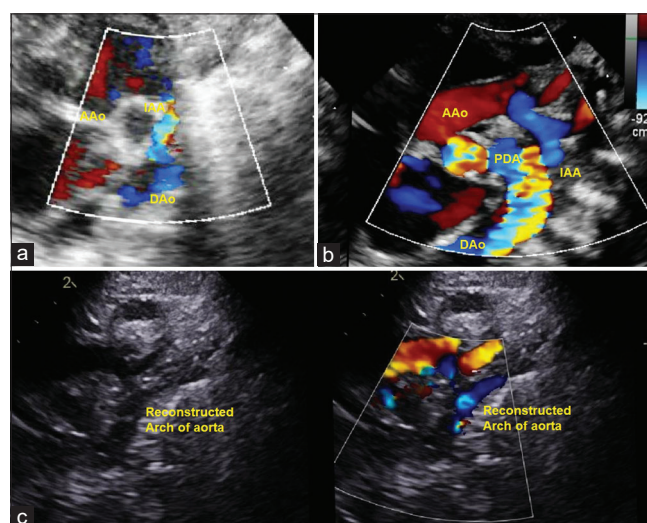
(a) Two-dimensional echocardiography with color Doppler showed interrupted aortic arch with segment after interruption supplied by flow from a tiny patent ductus arteriosus; (b) 12 h after starting prostaglandin echocardiography showed large patent ductus arteriosus continuing as descending aorta; (c) reconstructed aortic arch after surgical correction. (AAo: Ascending aorta, DAo: Descending aorta, IAA: Interrupted aortic arch, PDA: Patent ductus arteriosus)
